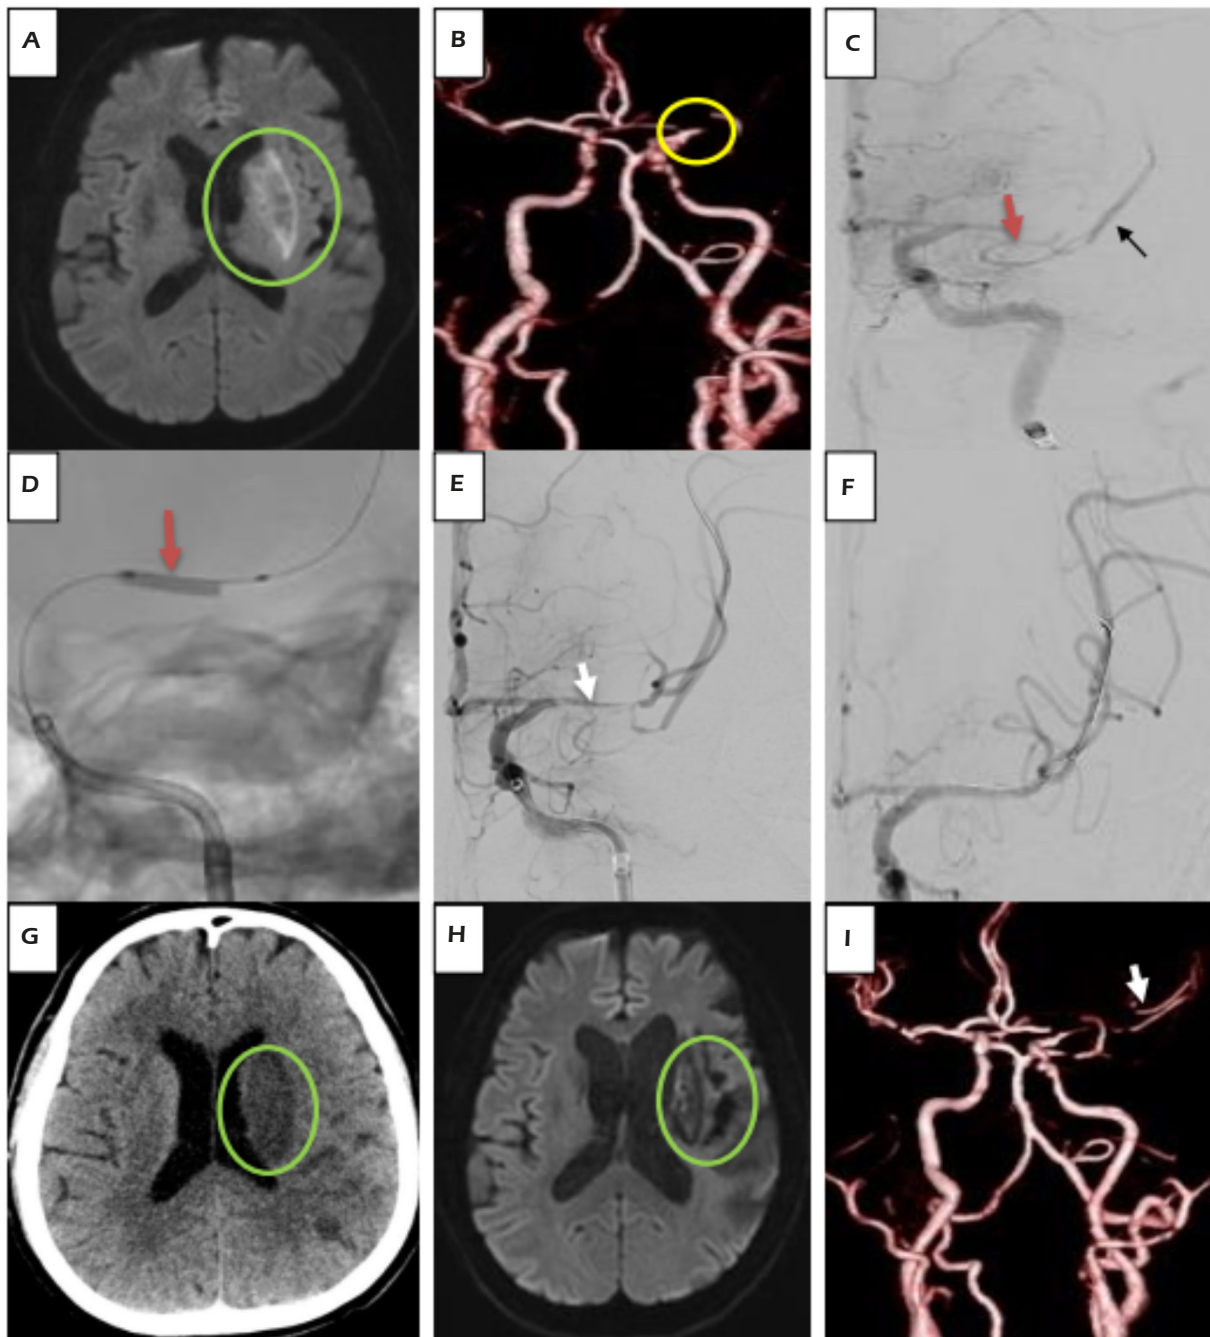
Sample case: A, Diffusion-Weighted Imaging-Alberta Stroke Program Early Computed Tomography Score of 7 (*green circle*). B, Magnetic resonance angiography revealed acute occlusion in the left middle cerebral artery (MCA) M1 segment (*yellow circle*). C, Digital subtraction angiography showed acute occlusion in the left MCA M1 segment (*red arrow*) and the distal M2 segment (*black arrow*). D, Angioplasty performed using a Gateway 2.0 × 15 (Stryker Neurovascular, Fremont, CA, USA) (*orange arrow*). E, Angiography following dilation (*white arrow*). F, Successful recanalization after the placement of a Wingspan 3.0 × 20 stent (Stryker Neurovascular, Fremont, CA, USA). G, Intracranial hemorrhage was excluded on the postoperative computed tomography scan (*green circle*). H, Left chronic infarct after 1 year (*green circle*). I, Left MCA M2 segment remained visible (*white arrow*).
